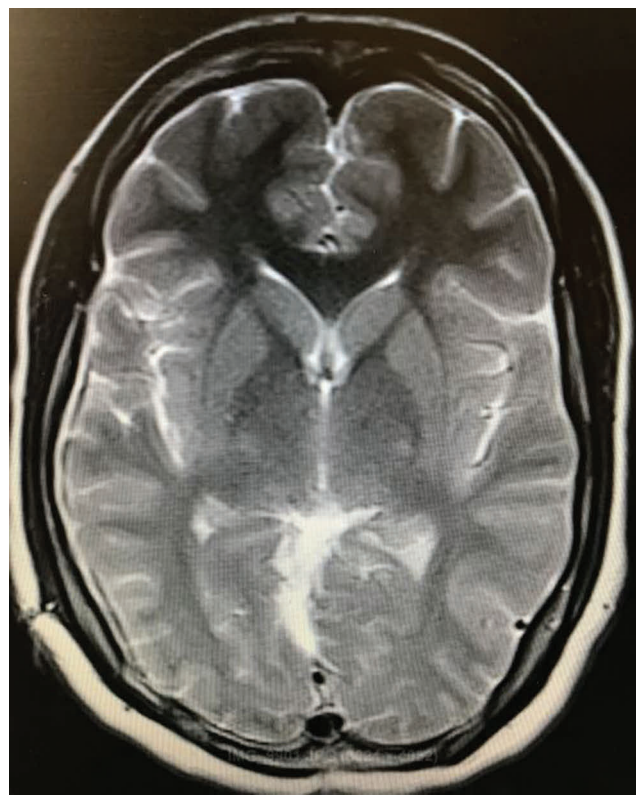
Postoperative MRI showing complete excision of the lesion.
